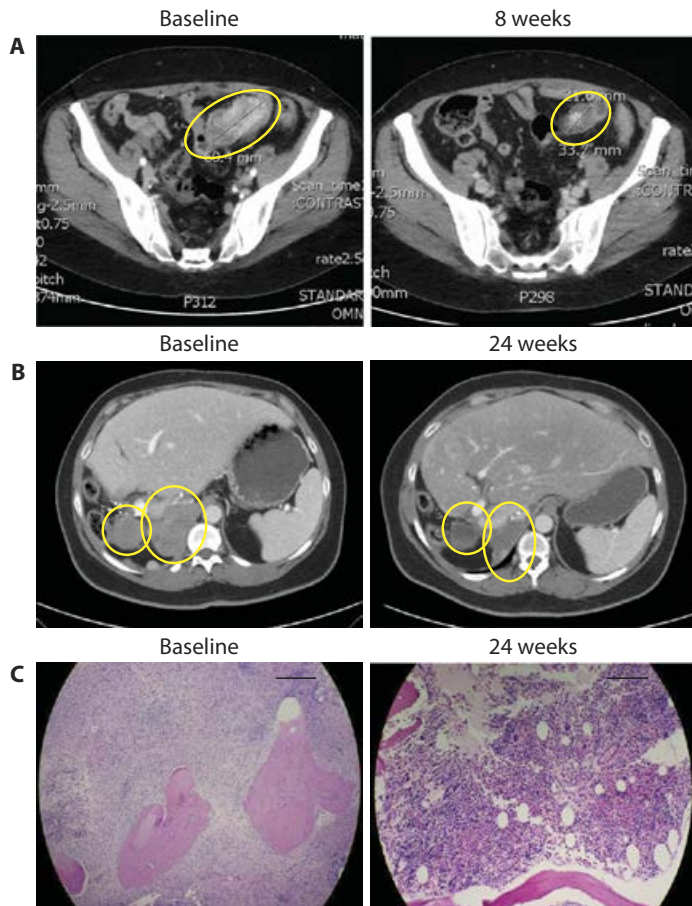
Clinical data with BLU-285 confirm early evidence of activity in patients with diseases driven by *KIT* and *PDGFRA* activation loop mutations. (A) BLU-285 [30 mg per os (PO), QD] induces rapid radiographic clinical response per RECIST1.1 (31% tumor reduction at week 8) and decline in *PDGFRA* D842V ctDNA in a patient with *PDGFRA* D842V-mutant GIST that progressed on previous imatinib, dasatinib, and crenolanib therapy. The images show CT scans with tumor circled in yellow. The graph shows tumor burden as measured by the sum of the longest dimension for the target lesions (per RECIST1.1) and mutant allele frequency (MAF). (B) Radiographic clinical response per RECIST1.1 with BLU-285 (60 mg PO, QD) in a patient with primary *KIT* D820Y-mutant GIST that had previously progressed on imatinib, sunitinib, and regorafenib. The images show CT scans with a pelvic tumor mass highlighted within yellow circles that demonstrated a 28% tumor reduction at day 1 of cycle 5. A partial response of 32% tumor reduction was confirmed by central radiographic review at cycle 15. (C) BLU-285 (30 mg PO, QD) markedly decreased bone marrow mast cell burden in a patient with *KIT* D816V-driven aggressive SM. At baseline, diffuse bone marrow infiltration with malignant mast cells obliterated normal hematopoiesis (left). After BLU-285 treatment, there was a marked reduction in malignant mast cells and return of normal trilineage hematopoiesis (right). Scale bars, 1000 μ m (left) and 200 μ m (right).
